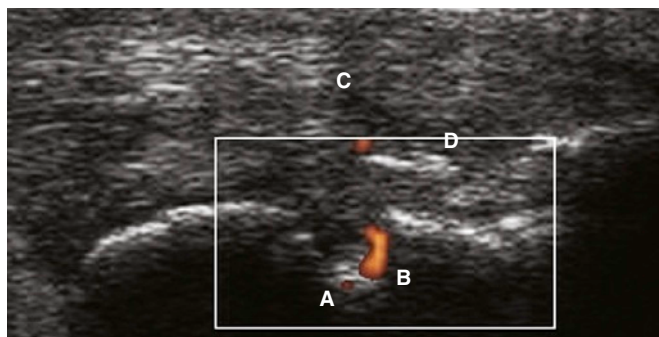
Ultrasound aspects of Achilles tendon enthesis in a longitudinal view include erosions (A), Doppler signal (B), hypoechoogenicity and increased thickness (C), and enthesophytes (D).
